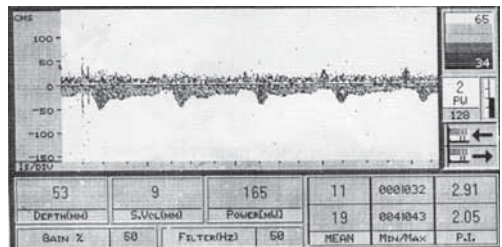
Transcranial continuous waveform Doppler of the right vertebral artery: there is a bidirectional flow with reduced peak systolic velocity (19 cm/s).
